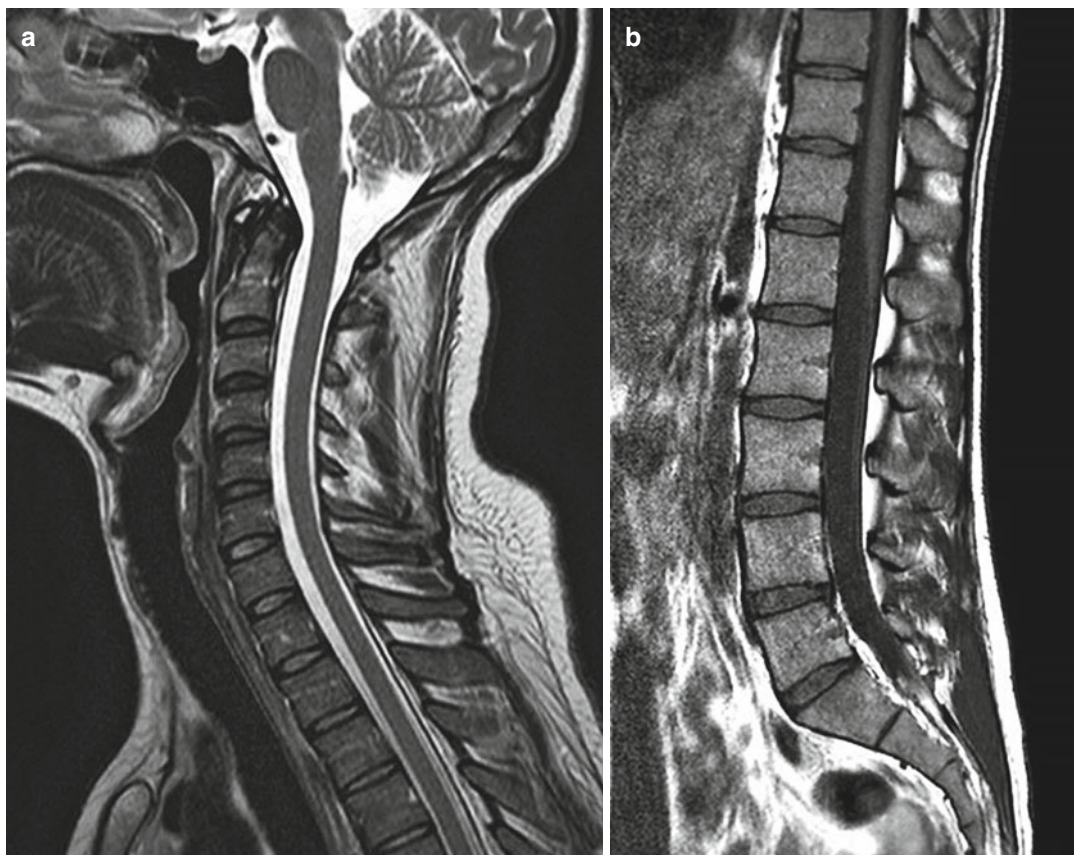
MRI, sagittal TSE T2-weighted (a) and T1-weighted images (b), respectively, of the cervical rachis and lumbar rachis. The vertebral cortical bone is
